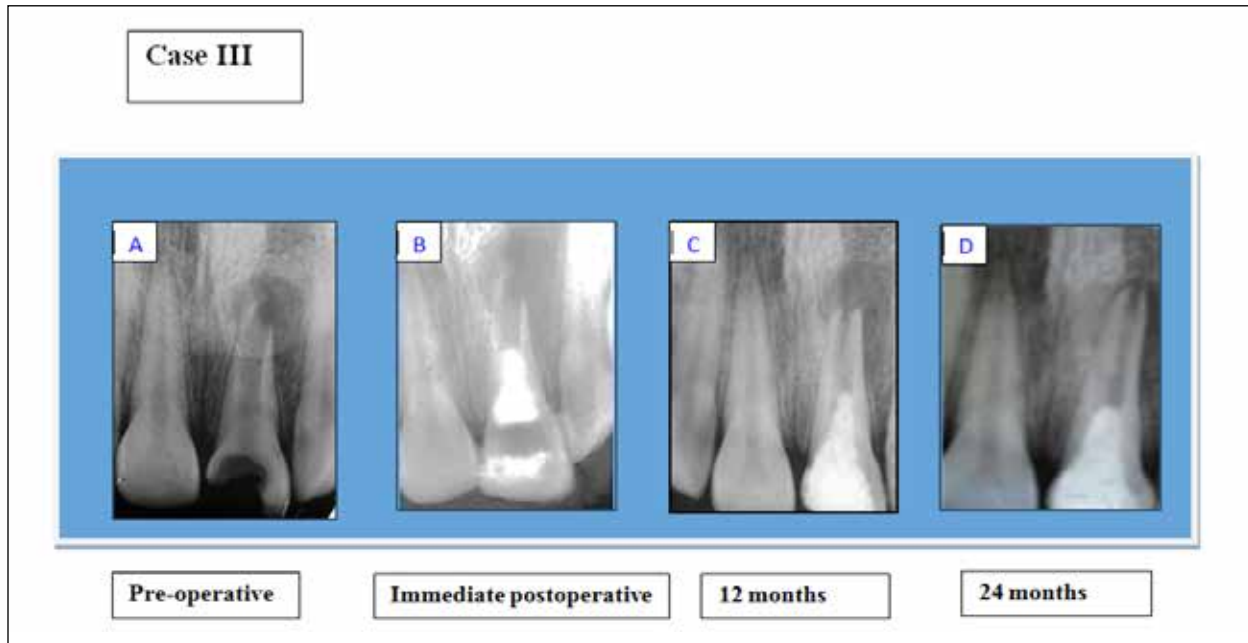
(A) Preoperative radiophotographs showed tooth # 21 having open apex with periapical radiolucency. (B) Immediate postoperative radiophotograph showing elongation of the root and reduction of periapical radiolucency. (C) 12 month postoperative radiophotograph showing elongation of the root and reduction of periapical radiolucency. (D) At 24-month follow-up, further narrowing of root canal in the apical third and thickening of the lateral walls were evident with resolution of the periapical radiolucency
